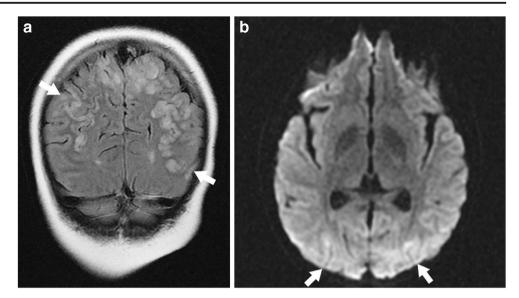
Systemic-onset juvenile idiopathic arthritis and macrophage activation syndrome in a 10-year-old girl with seizures. a Coronal fluid-attenuated inversion recovery (FLAIR) MRI of the brain shows bilateral occipital cortical high signal intensity (*arrows*). b Axial diffusion-weighted MRI shows diffusion restriction of the bilateral occipital lesions (*arrows*). These findings are in keeping with posterior reversible encephalopathy syndrome
